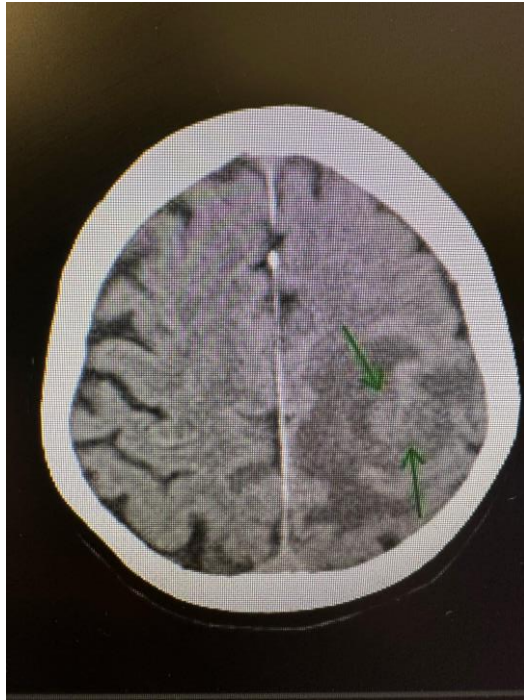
4.5 x 2.5 x 3.4 cm with surrounding edema on CT head without contrast
